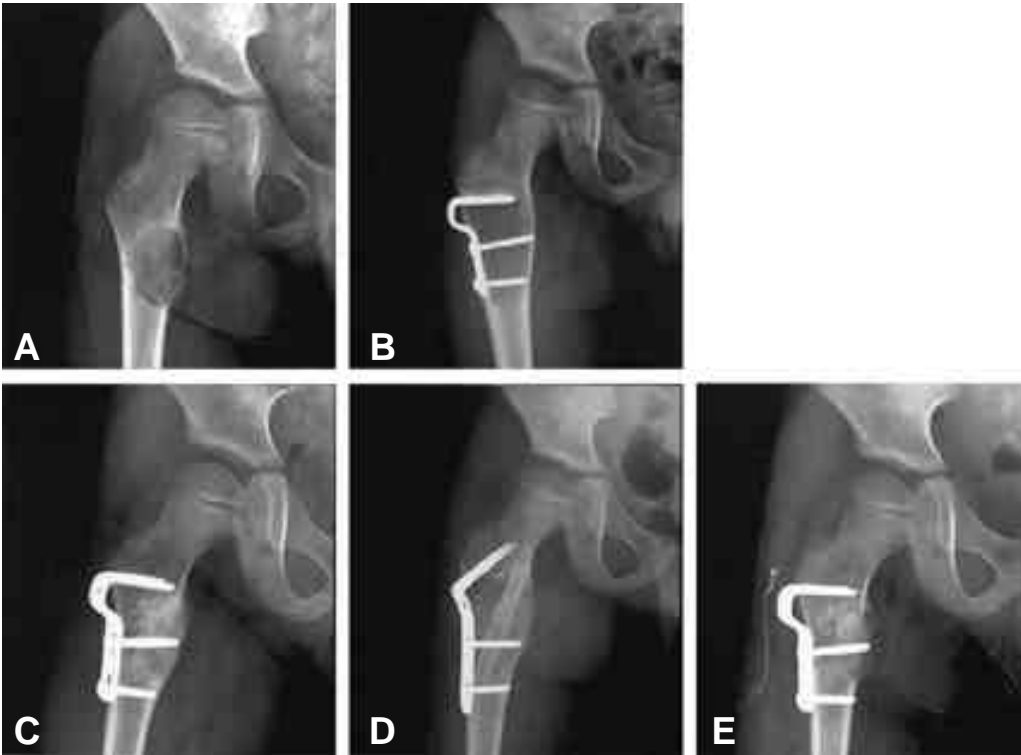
Simple bone cyst of proximal femur in 5 years old boy. (A) Preoperative AP radiograph shows bone loss in proximal femur. (B) Immediate postoperative radiograph taken after curettage and defect filling with fresh frozen allograft alone. (C) At postoperative 9 weeks, bony trabeculation fills a preoperative lytic lesion. (D) At postoperative 7 months, the recurrence of disease was observed (E) The curettage which was through and allograft with fibular strut graft was done.
